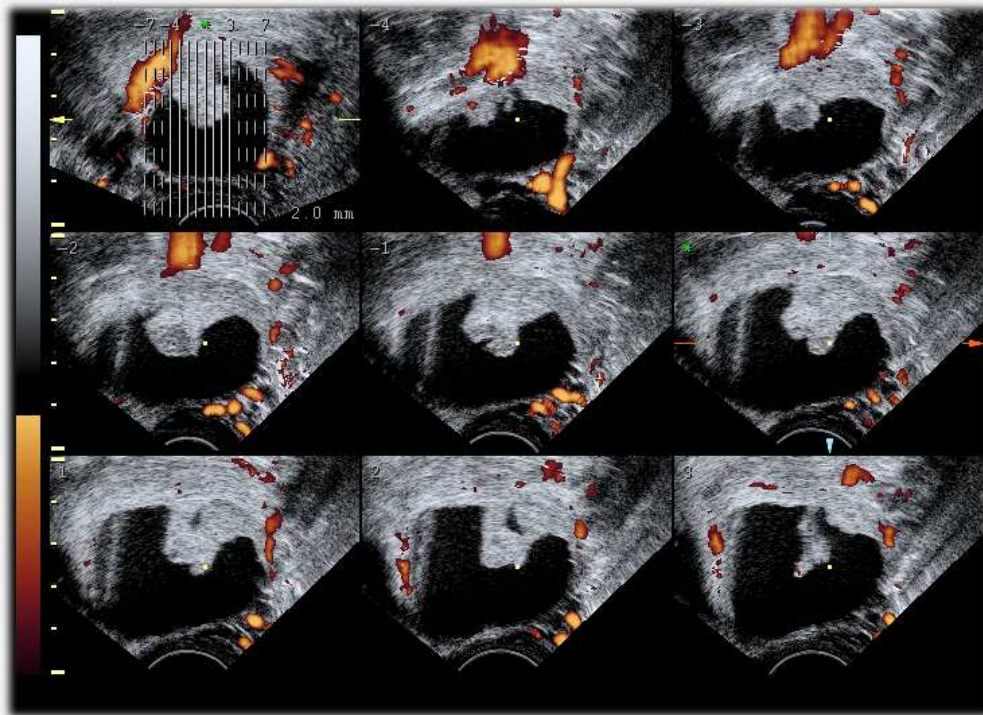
3D Power Doppler ultrasound by the Tomographic Ultrasound Imaging (TUI) allows the visualization of a complex cyst. Multiple slices above clearly show in each image completely absence of vascularization in the papillation.
